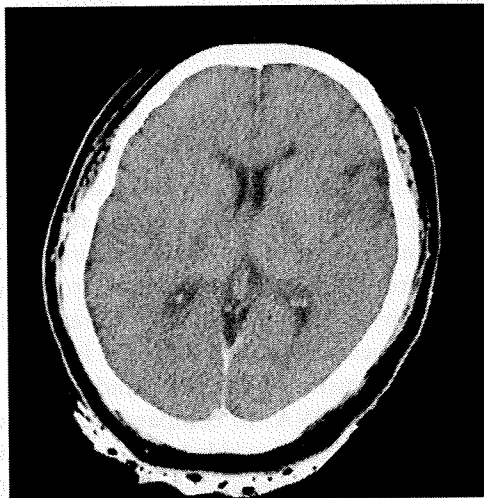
A 37-year-old woman. Postmortem computed tomography (CT) scan of the brain performed 36 h after confirmation of death shows loss of the gray–white matter interface, obscuration of the lentiform nucleus, and sulcal effacement
